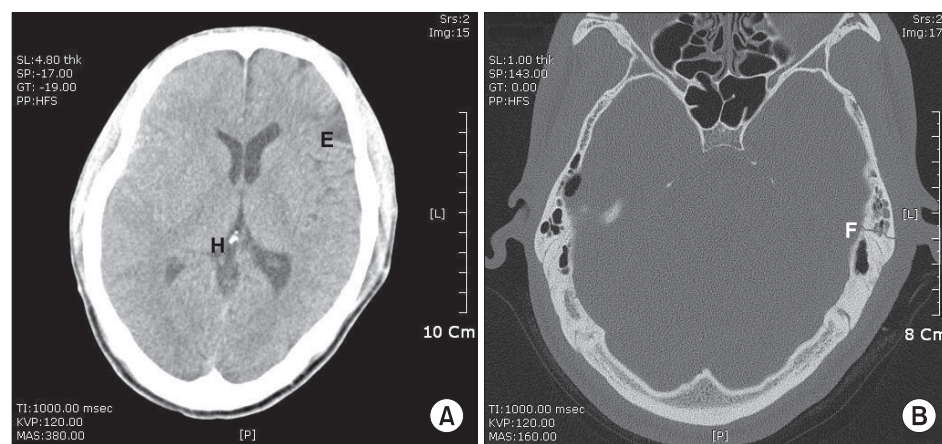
Brain CT shows subarachnoid hemorrhage, right fronto-temporal convexity and multi-focal encephalomalacia of the left frontal and temporal lobes due to old brain contusion (A). Also, Linear skull fracture of the left temporal bone was detected (B). E: encephalomalacia, F: linear skull fracture, H: subarachnoid hemorrhage.
